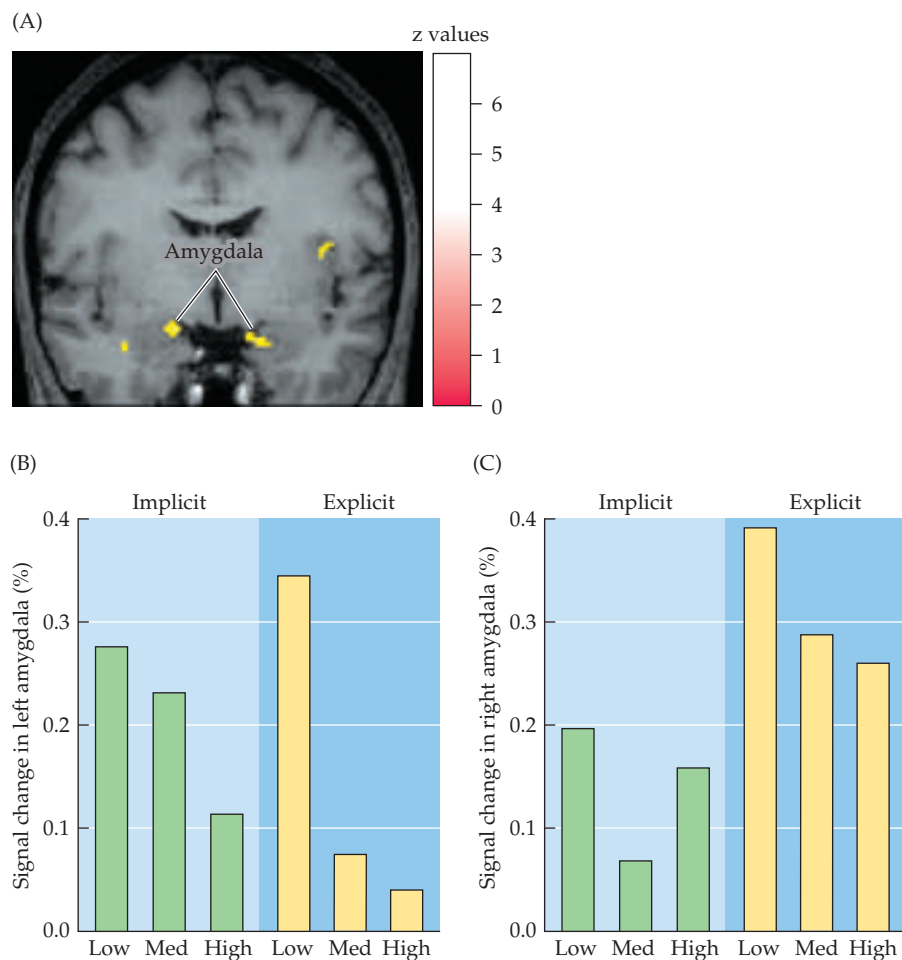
Activation of the amygdala during judgments of trustworthiness. (A) Functional MRI shows increased neural activation bilaterally in the amygdala when normal subjects appraise the trustworthiness of human faces; activity is also increased in the right insular cortex. (B, C) The degree of activation is greatest when subjects evaluate faces that are considered untrustworthy (Low, Med and High indicate ratings of trustworthiness; Low = untrustworthy). The same effect was observed when subjects were instructed to evaluate the trustworthiness of the faces (explicit condition) or whether the faces were those of high school or university students (implicit condition). (After Winston et al., 2002; A courtesy of J. Winston.)
